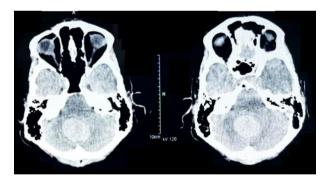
First brain CT after development of signs and symptoms of cerebellar dysfunction, showing tumor in the cerebellum.
